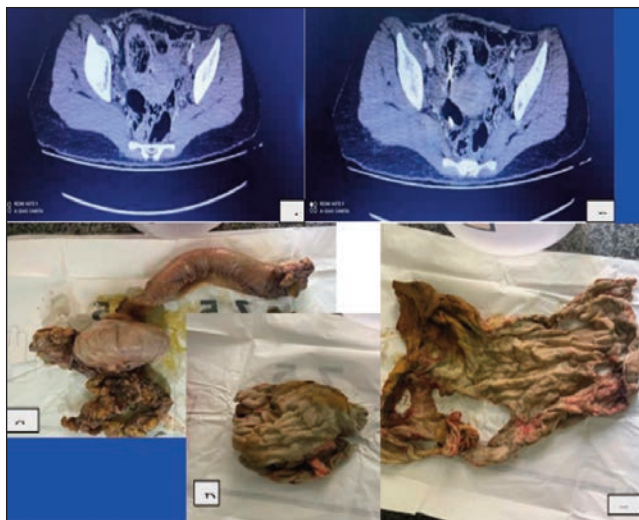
(A) CT scan of case 3: sponge from appearance of mass with surgical needle like artefact. (B and C) Surgical sponge with thread and needle making adhesions with small gut.
